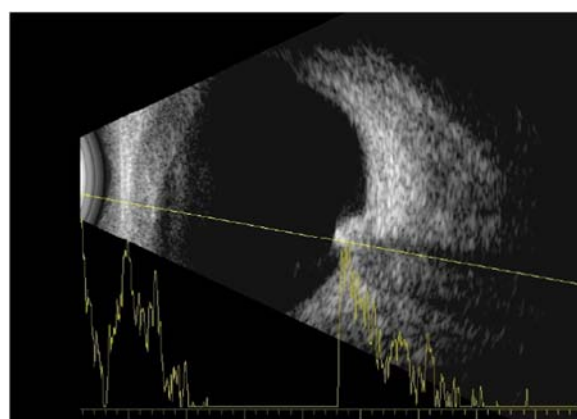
B scan ultrasonography showing a small dome-shaped lesion arising from the optic disc with high internal reflectivity with orbital shadowing.
